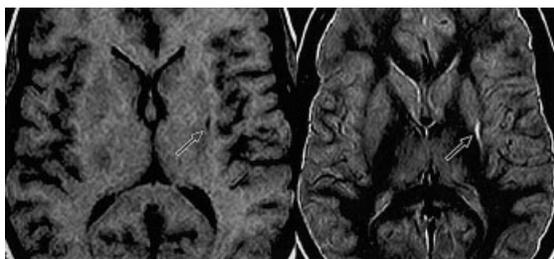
Axial T1-weighted (left) and proton density (right) magnetic resonance images. The arrows mark the abnormal signal in the posterolateral left putamen, consistent with gliosis. The lesion is also high signal on T2 and FLAIR sequences. The putamen is smaller on the left than the right, especially the posterior portion of the nucleus. The internal capsule and globus pallidus are of normal signal intensity.
